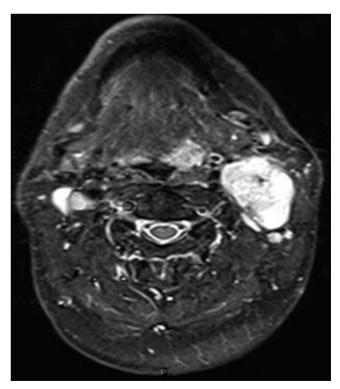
An axial short tau inverted-recovery (STIR) sequence magnetic resonance image (MRI) of a T2N2b carcinoma of the left base of tongue.
